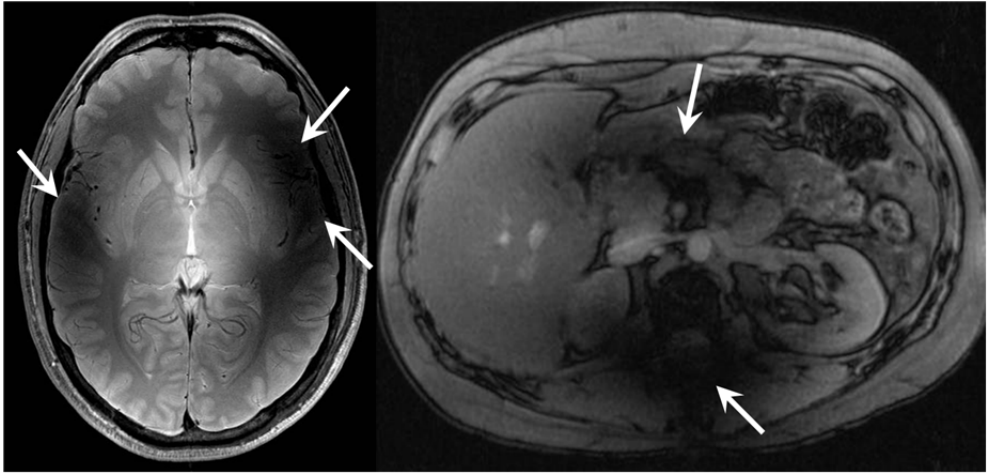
Two MR images with visible signal dropouts due to inhomogeneous excitation (arrows) acquired at 7 Tesla. On the left an axial spin echo image of a human head is shown, on the right an axial gradient echo image of the human abdomen.
